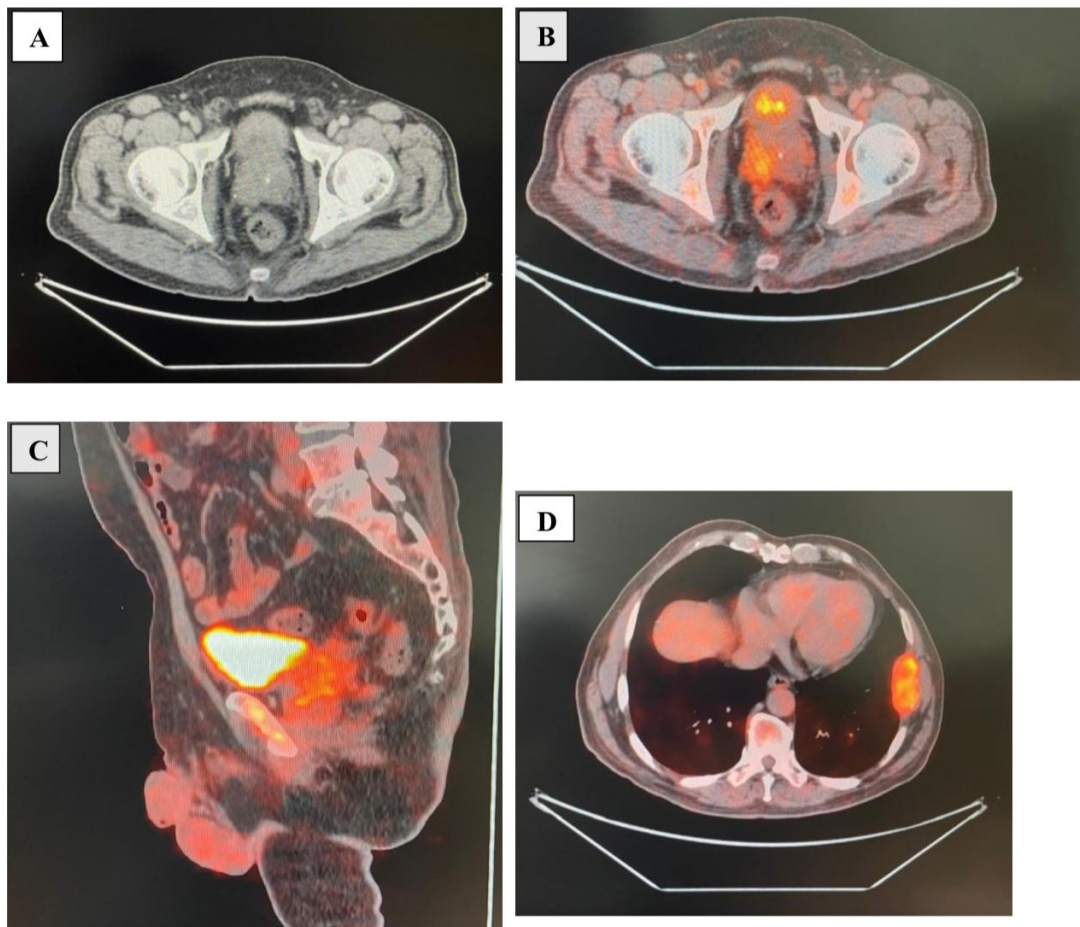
(A-D) FDG avid heterogeneously enhancing large mass lesion involving both lobes of the prostate gland, predominantly involved the right half of the prostate associated with peri-prostatic infiltration with loss of fat planes with bilateral seminal vesicles and the posterior wall of the urinary bladder. FDG-avid multiple sclerotic-lytic lesions were seen involving the shafts of multiple ribs on both sides, the largest involving the shaft of the 7th rib on the left side (SUV = 7.48 gm/ml).
